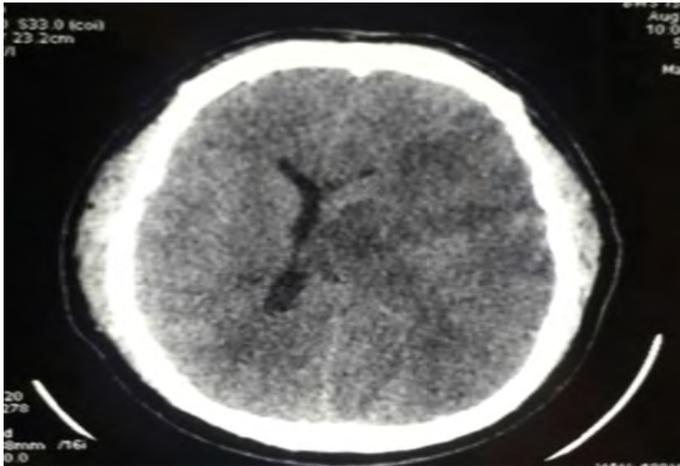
Axial section of cerebral CT showing infarctus in the territory of the left middle cerebral artery.
